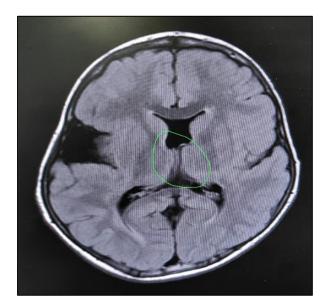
MRI Brain shows the presence of an interhemispheric fissure along the entire midline (encircled), and an arachnoid cyst in the right anterior temporal fossa.
